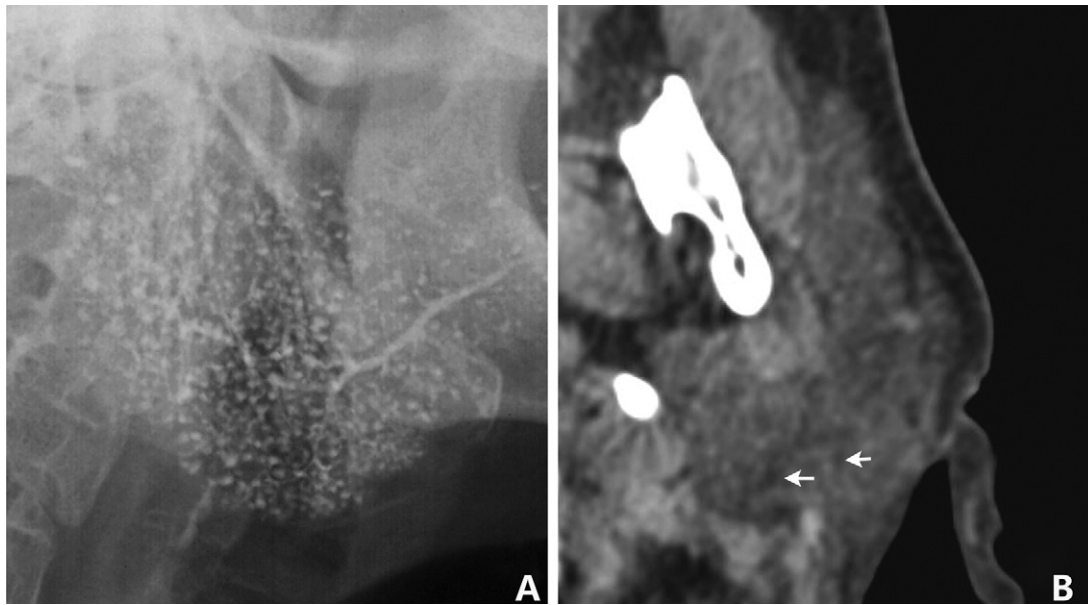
Sialogram and CT in stage 1 of SS. Note the punctate to round sialectasis in the sialogram (A) and the heterogeneous diffuse punctate abnormal adipose tissue accumulation (B, white arrows) in a stage 1 patient (45-year-old, female).
